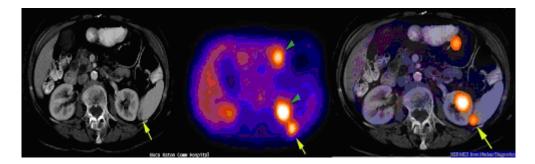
Determining the exact localization of the lesion by overlaying CT and PET images on top of each other, fusion imaging (14).
